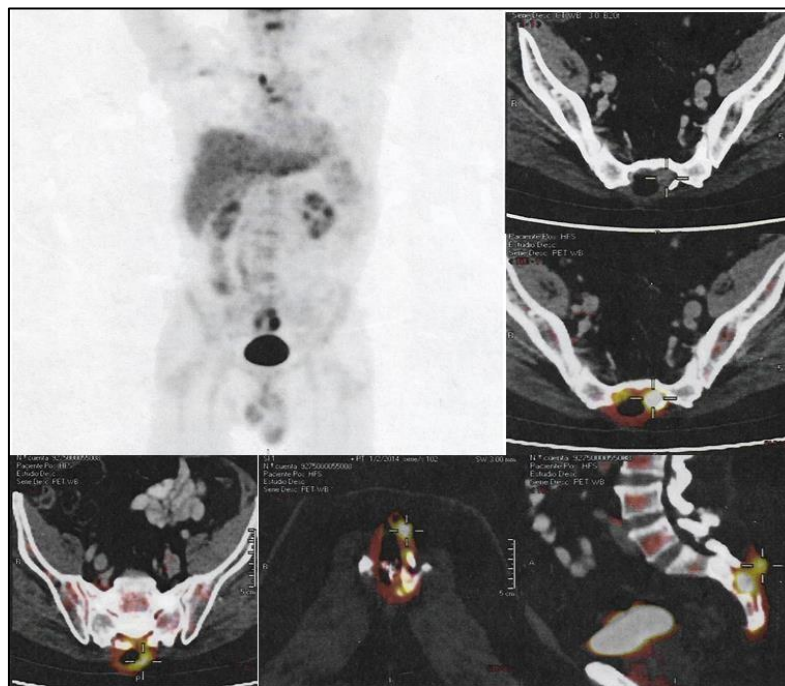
SPECT-CT Indian octreotide 110 images
